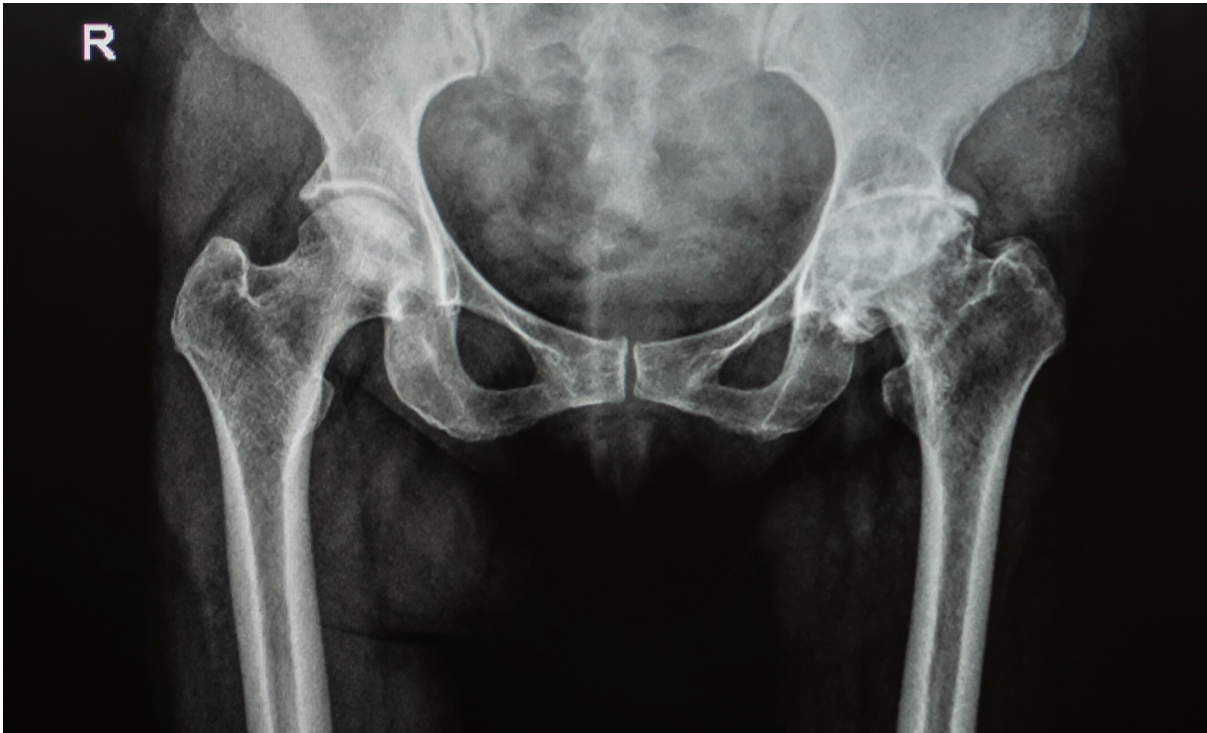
Figure Intro 2. AP pelvic radiograph showing OA of LEFT hip with loss of joint space, osteophytes and a large supra-acetabular cyst (purchased stock image from shutterstock.com)
